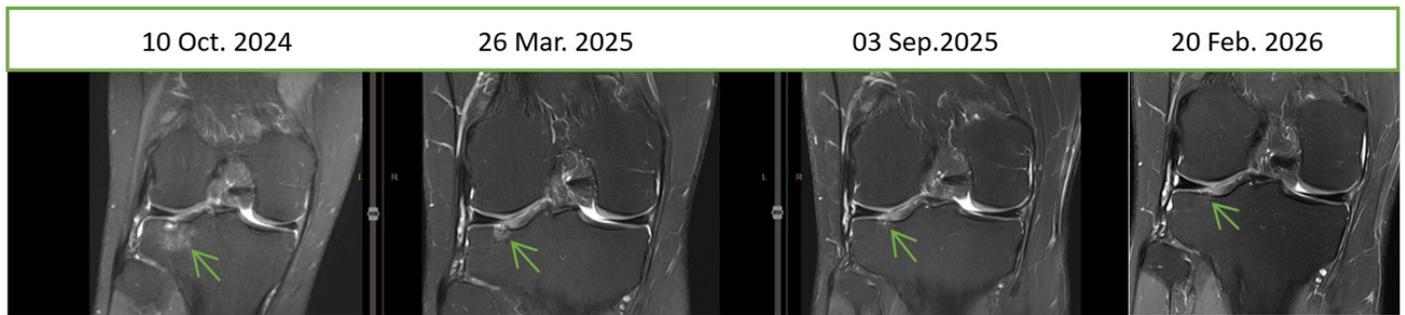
Coronal T2-weighted MRI demonstrating interval resolution of the osteochondral defect following repeated platelet-rich plasma therapy.
